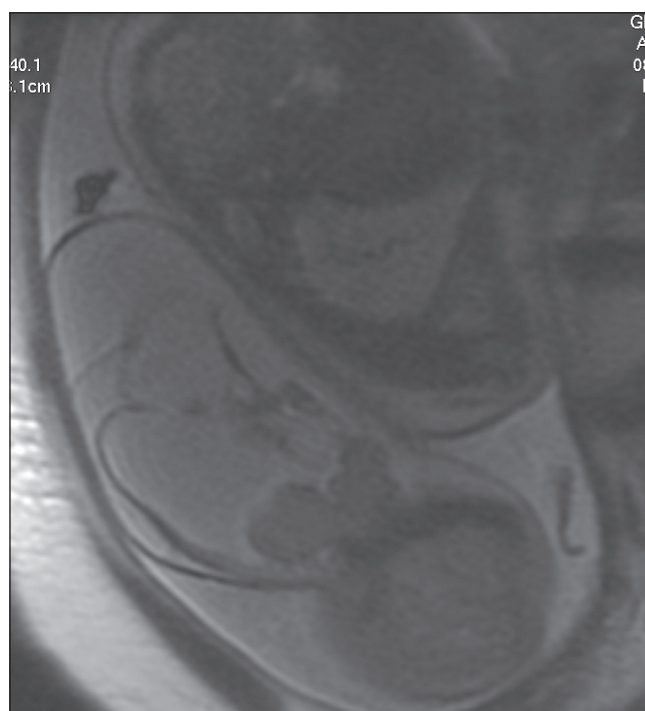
T2-weighted MR image demonstrating a large occipital encephalocele, as well as parenchymal information (grey-white matter differentiation).
